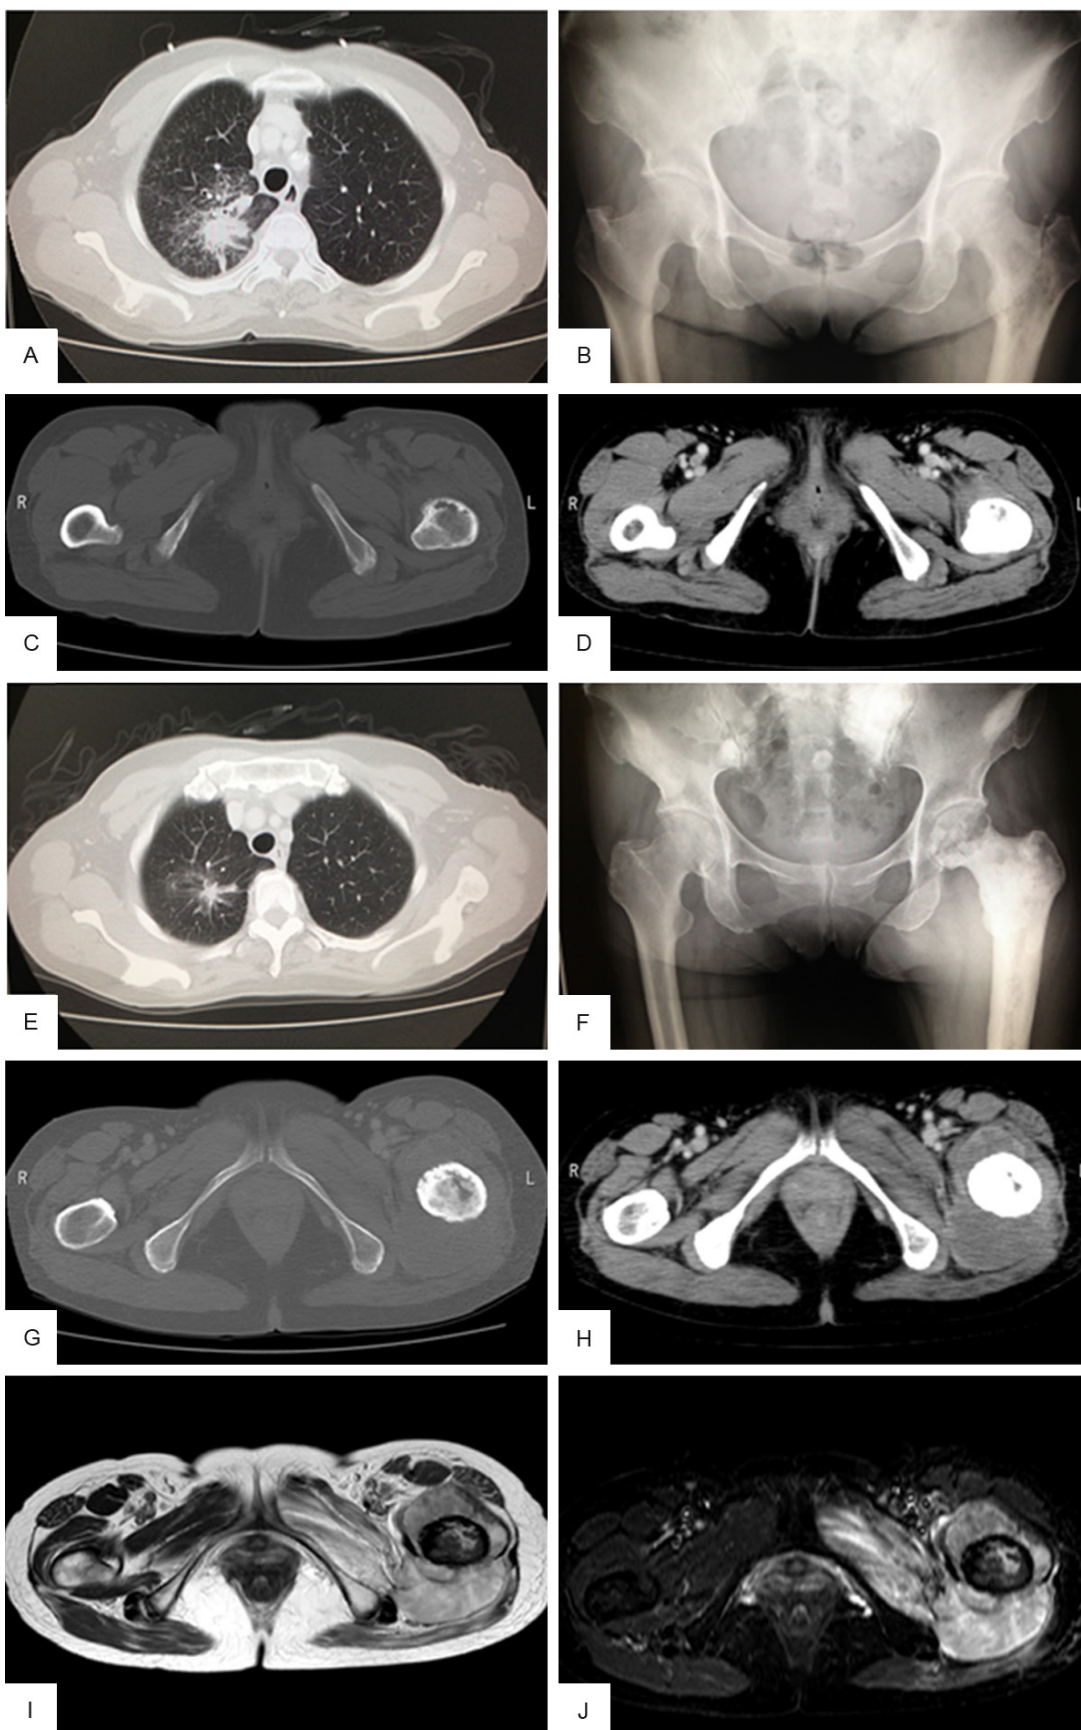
Presurgical imaging of the primary tumor and femoral metastasis. (A) Computed tomography (CT) of the chest showed a high-density nodular mass before gefitinib treatment. (B) Plain radiography revealed an osteolytic lesion in the left proximal femur before gefitinib treatment. (C, D) Contrast enhanced CT of the femurs and pelvis showed a thin cortex in the left femur with no soft tissue mass before gefitinib treatment. (E) Chest CT taken during gefitinib treatment and irradiation revealed marked shrinkage of the tumor. (F) Plain radiograph taken before surgery showed an osteosclerotic lesion with osteolytic change in the left proximal femur and decreased permeability into the surrounding soft tissue. (G, H) Enhanced CT taken before surgery revealed an isodense mass within the bone marrow and surrounding soft tissue. (I, J) Magnetic resonance imaging performed before surgery revealed a mass with isointensity on T2-weighted images (I) and with heterogenous intensity on fat-suppressed T2-weighted images (J) around the left femur.
